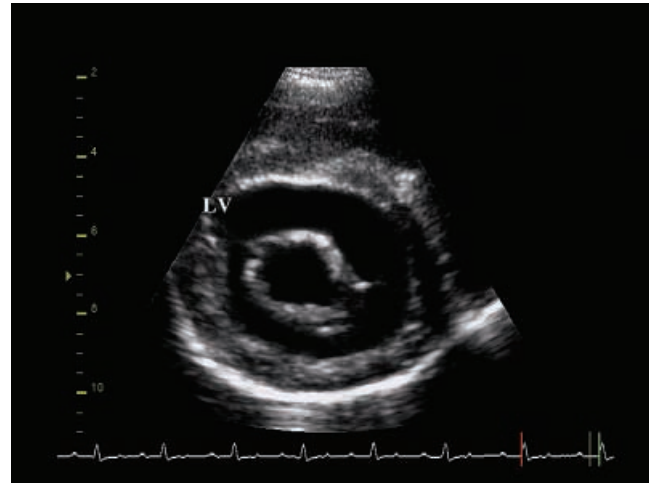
Two-dimensional echocardiogram (right parasternal short-axis section of the ventricles). The maximal mitral valve opening was seen on this diastolic frame, which permitted to calculate the mitral valve area by tracing the inner area of the mitral valve orifice. The area of the left ventricle (LV) was measured in the same frame.
